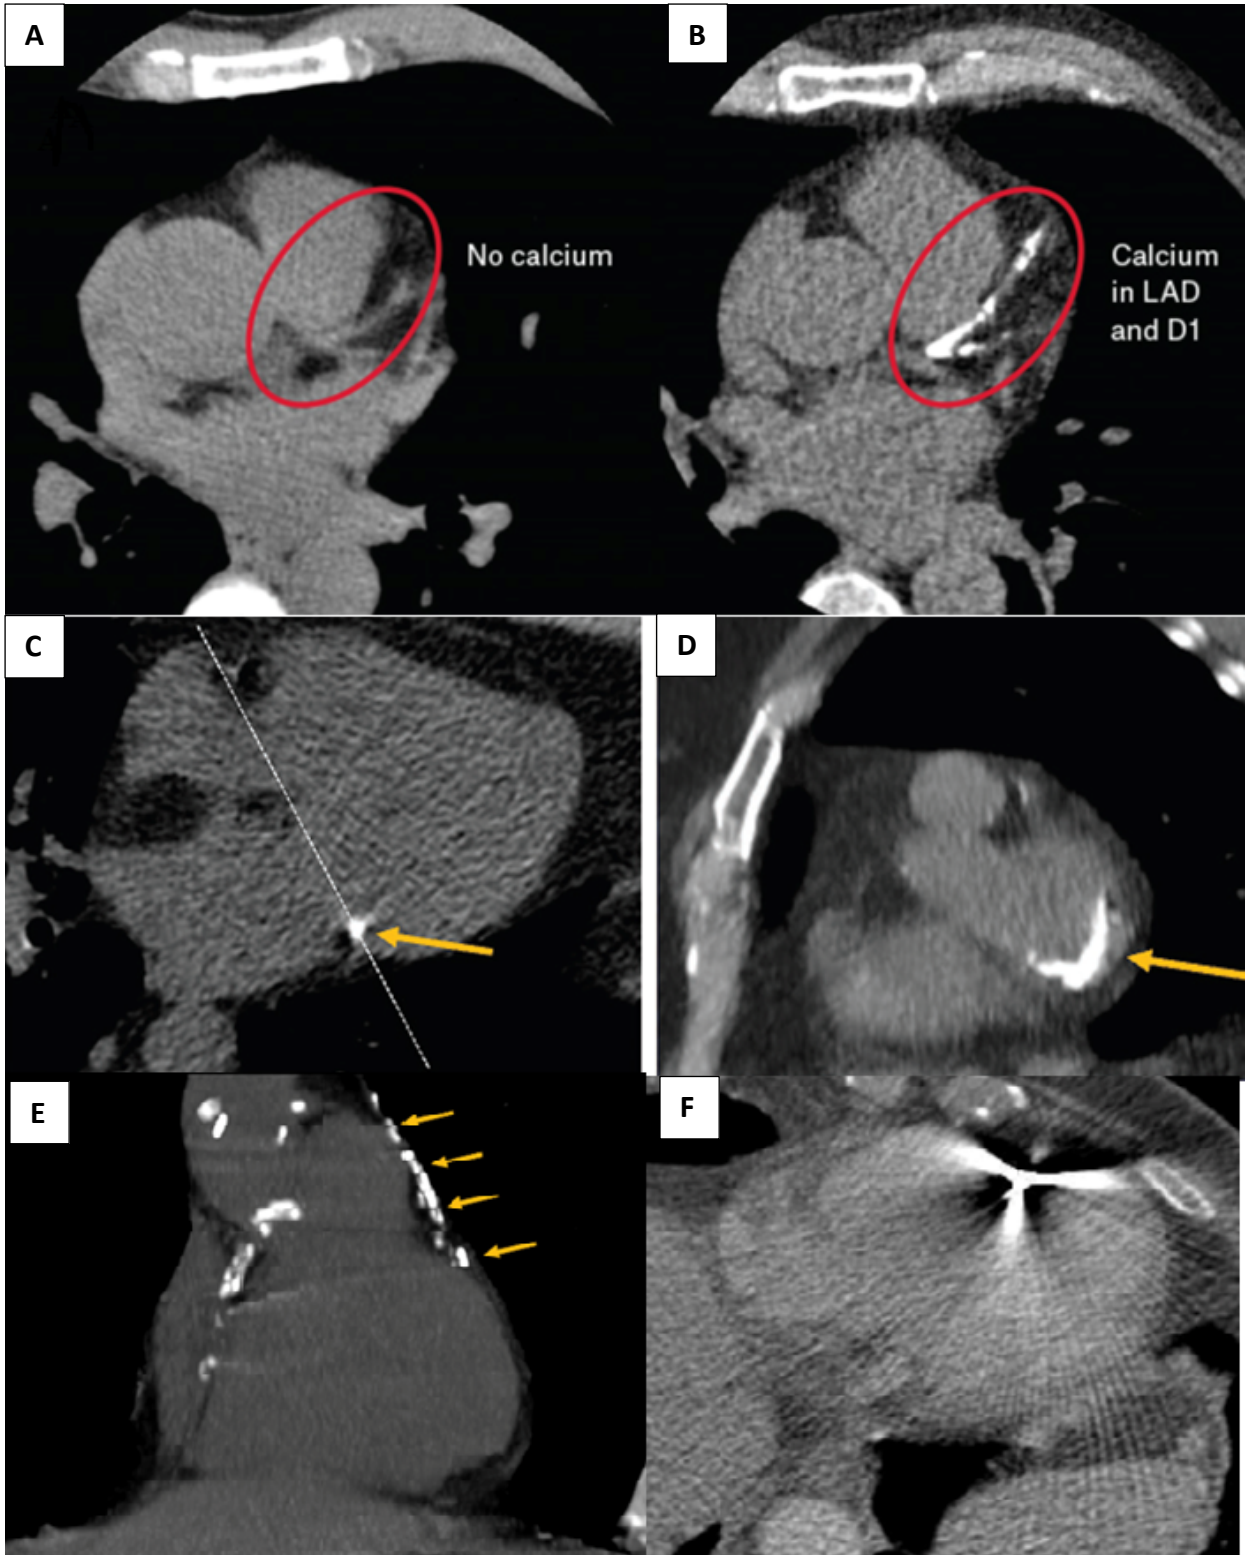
A,B) Distribution of coronary calcium on cardiac CT in two different patients: no detectable coronary calcium (A), coronary calcium in epicardial coronary arteries (B), including the left anterior descending and diagonal artery. C,D) distribution of calcium in the mitral valve. E) Evidence of coronary artery calcium, the yellow arrows indicate pericardium cardiac calcium. F) the presence of electrode impedes coronary calcium assessment.
